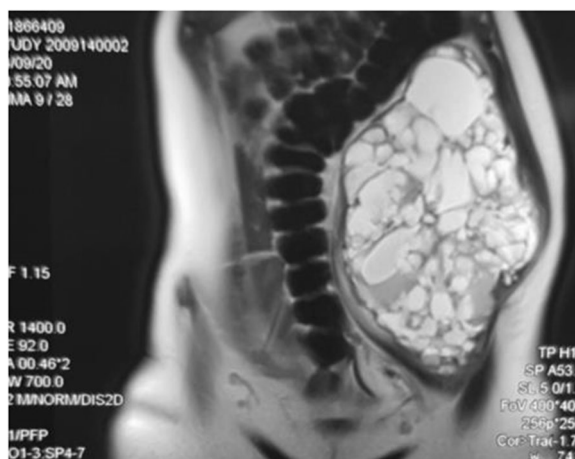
MRI of the lesion
